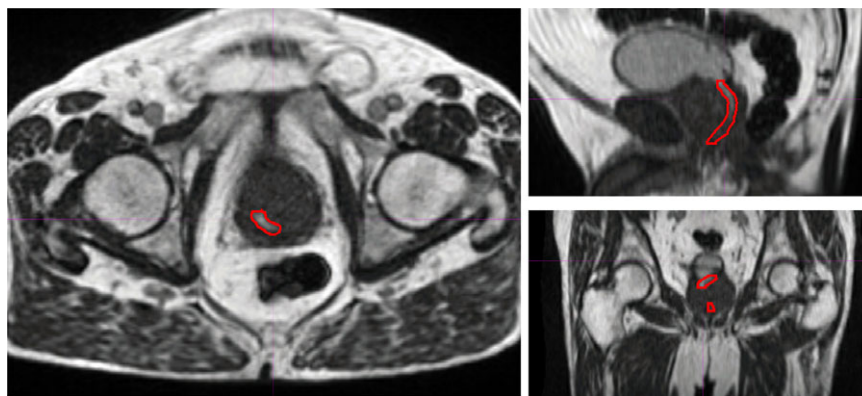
MRI showing the visible proximal urethra during voiding, contoured in red, with increased signal intensity shown as urine passes from the bladder through the urethra.
